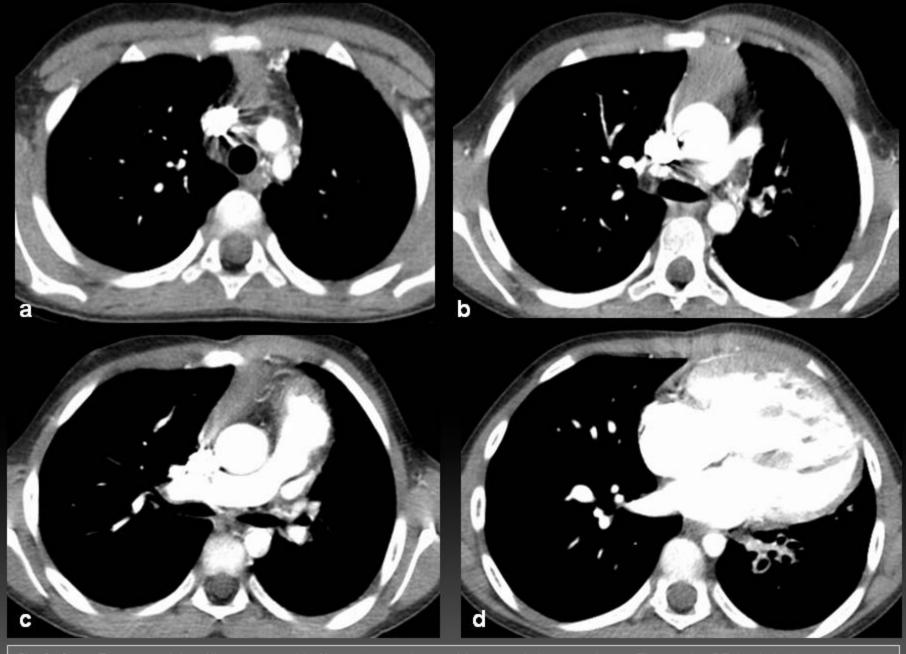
Boy, 7 years old, with recurrent left pneumonia and hemoptoic spuctum. Thoracic CT (axial planes) shows hypertrophy of left bronchial arteries (a,b), absence of left pulmonary artery and its branches (c,d), hypoplasia of ipsilateral lung and cardiomegaly (d).
